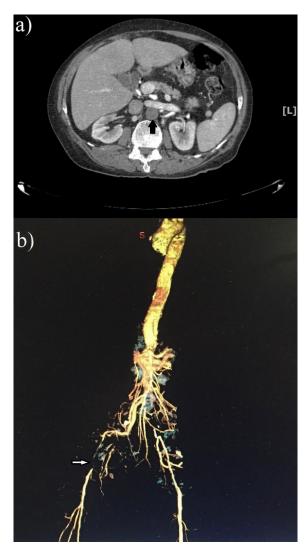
Computed tomography angiography (CTA) demonstrates the aorta through the lower extremities. a) Axial image demonstrates the complete thrombosis of the abdominal aorta (arrow). b) Three-dimensional reconstruction reveals right iliac artery occlusion (arrow).
